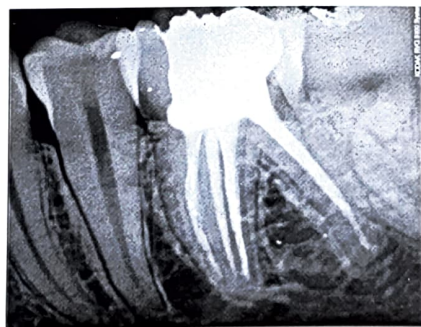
CASE II: Obturation radiograph
